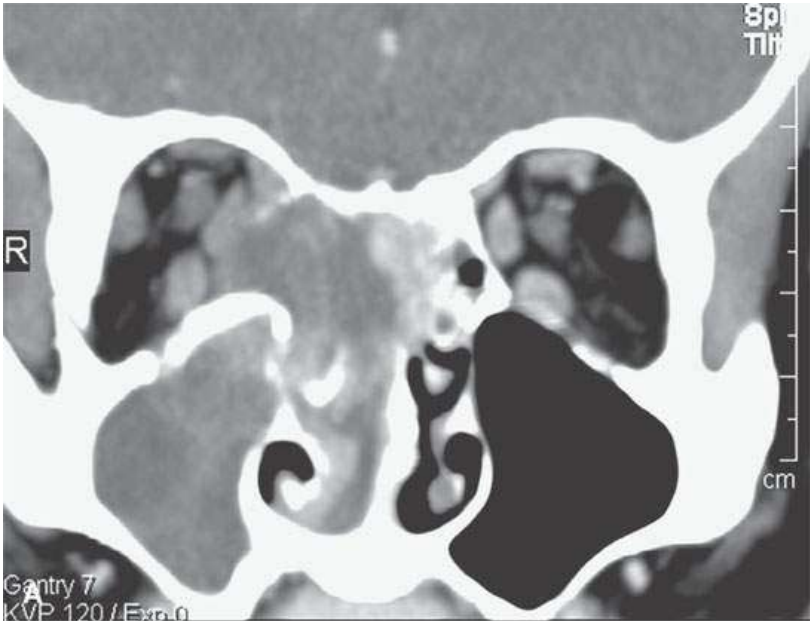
Contrast-enhanced computed tomography of primary sinonasal lymphoma with orbital invasion and spread to the orbital apex (arrow in B) threatening optic nerve function.
